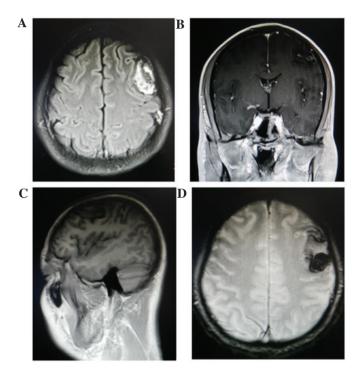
(A) Horizontal, (B) coronal and (C) sagittal pre-operative MRI scans of the left frontoparietal region revealed a mass with a signal intensity higher than that of the grey matter on T1-weighted images. (D) Postoperative cranial MRI revealed no residual tumor. MRI, magnetic resonance imaging.
